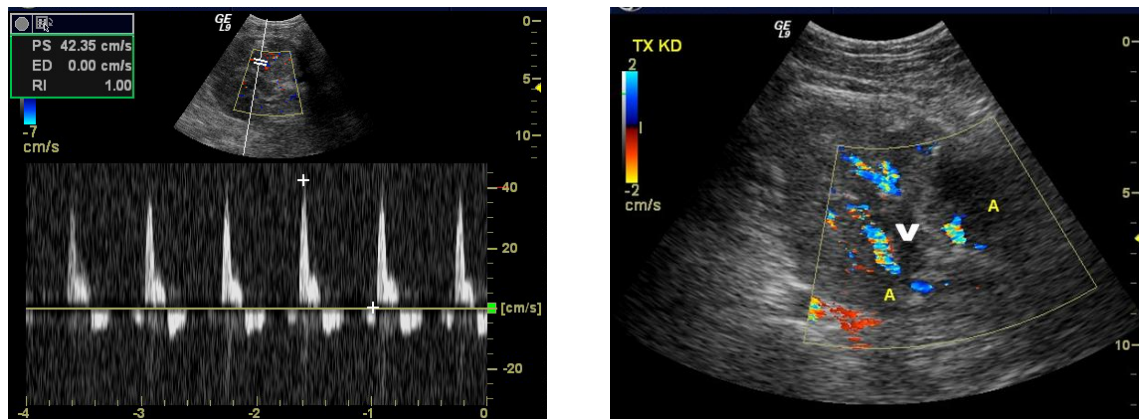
Renal vein thrombosis. (A), Doppler US of an intrarenal arcuate artery shows reversal of the diastolic flow below the baseline. (B), color Doppler image through the renal hilum shows two renal arteries (A) with no flow in the central renal vein (V) consistent with renal vein thrombosis.
